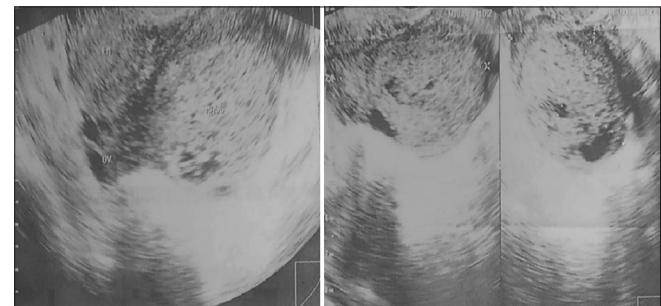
Ultrasound of the Right Ovary. The right ovary measures $3.90 \text{ cm} \times 3.53 \text{ cm} \times 2.14 \text{ cm}$ with a solid area measuring $2.55 \text{ cm} \times 2.2 \text{ cm} \times 1.95 \text{ cm}$. Adherent to the right ovary is a solid mass measuring $5.89 \text{ cm} \times 6.76 \text{ cm} \times 4.40 \text{ cm}$ with cystic spaces within
